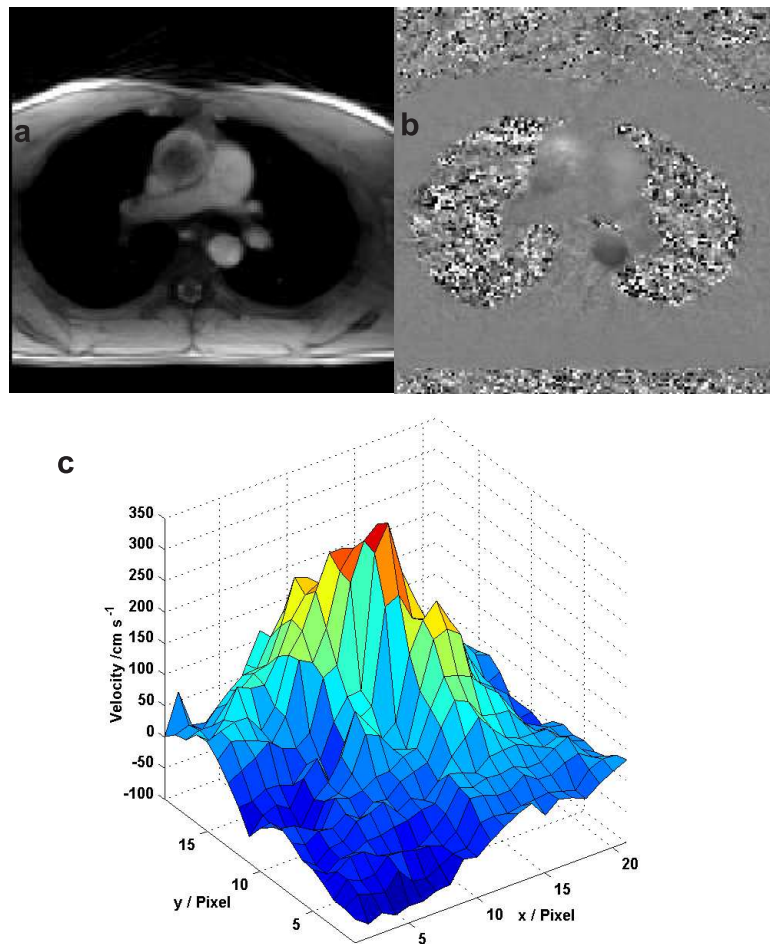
Transverse view of the human heart at the region of ascending aorta: (a) magnitude image, (b) phase-contrast map and (c) flow profile of blood flow during mild aortic valve insufficiency using real-time PC MRI. The scan parameters were TR/TE/ α = 2.64/1.84 ms/10°, spatial resolution $1.3 \times 1.3 \times 6$ mm³, 2×7 spokes and 5 interleaves, VENC 250 cms⁻¹, temporal resolution 37 ms, 27 fps.
